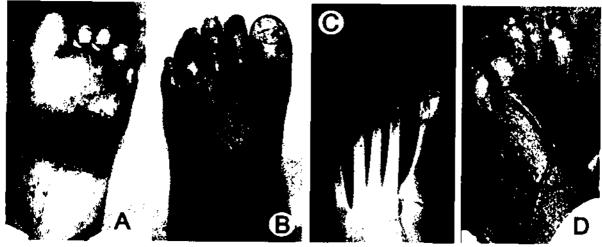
This 60-year-old female with diabetes and a history of plantar callus presented with (A) ulceration sub 4th metatarsal head and (B) 4th left toe, and poor diabetic control. A severe foot infection was apparent and (C) radiographs showed erosive disorganization of the 4th MTP joint. The patient developed a foot infection secondary to the plantar callus that progressed to osteomyelitis of the 4th toe and 4th metatarsal. (D) She was treated with parenteral antibiotics and ray resection.
